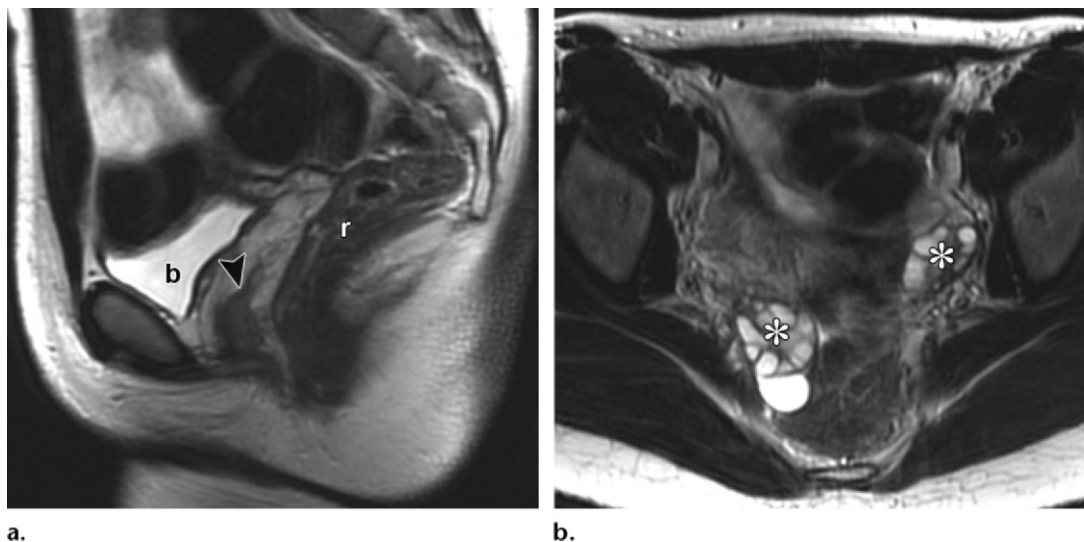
Mayer-Rokitansky-Küster-Hauser syndrome. (a) Sagittal T2-weighted MR image shows complete absence of the cervix and uterus with an abnormally truncated vagina ending in a blind pouch (arrowhead) between the rectum (*r*) and urinary bladder (*b*). (b) Axial T2-weighted image shows the presence of normal ovaries (*).
